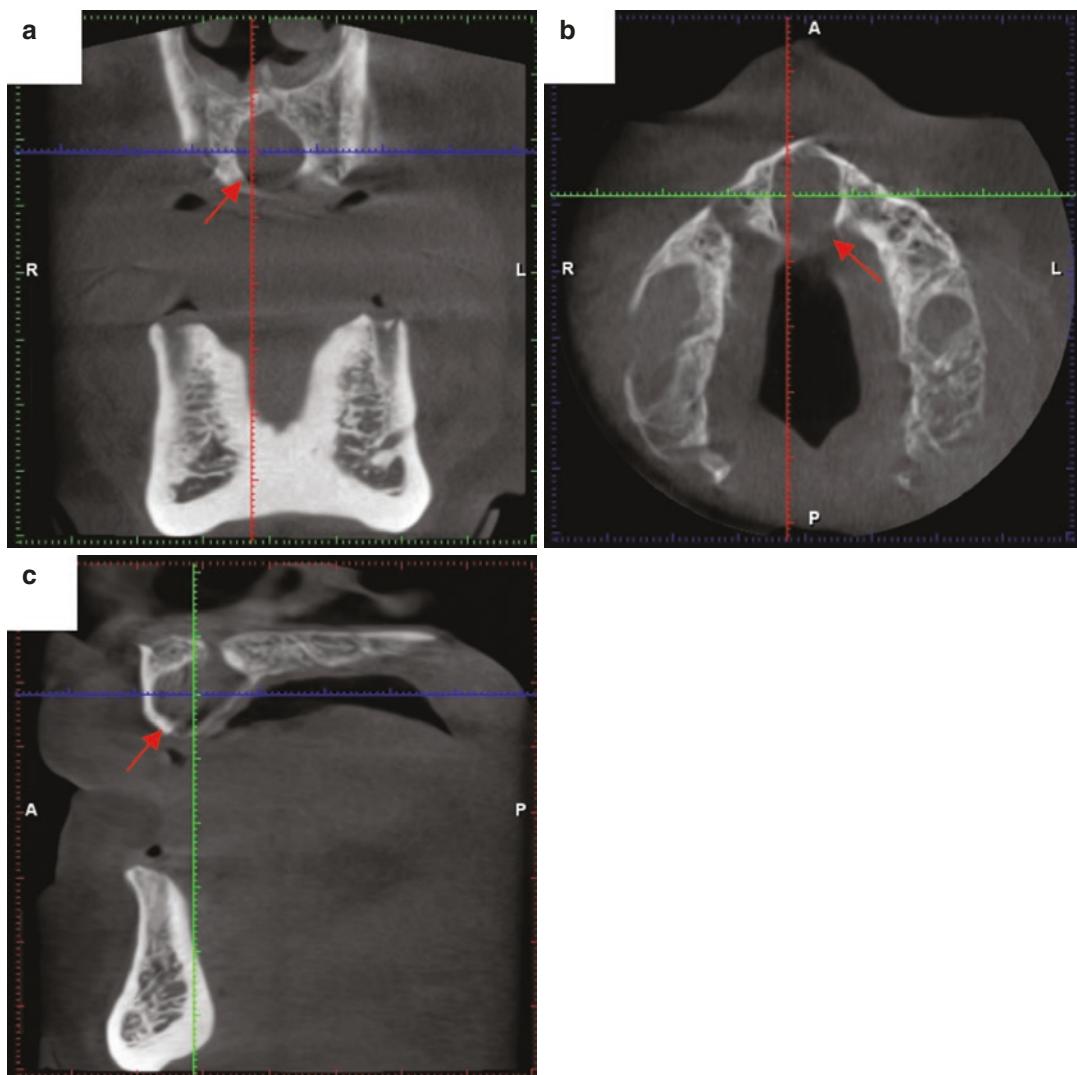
Coronal (a), axial (b), and sagittal (c) images show midline incisive canal cyst vs. enlarged incisive foramen in a 62-year-old male. CBCT scan was taken for implant treatment planning. Diameter of the well-defined
